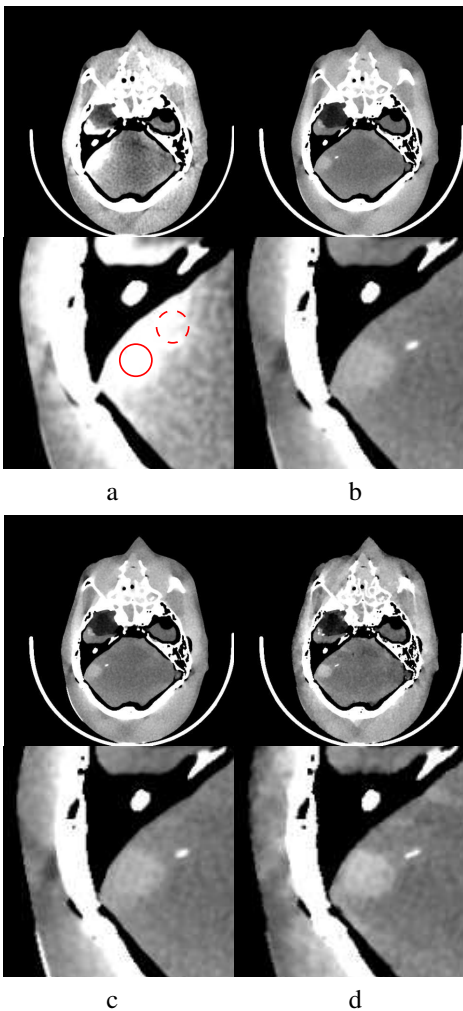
Reconstructions and the corresponding zoomed-in views of ROI images within the transverse slice reconstructed from 1200-view data by use of the FDK algorithm (a) and the CP algorithms with data- $\ell_2$  fidelity (b), data- $KL$  fidelity (c), and data- $\ell_1$  fidelity (d). The narrow display window [0, 100] HU is used to reveal the details of the cone-beam artifacts.
